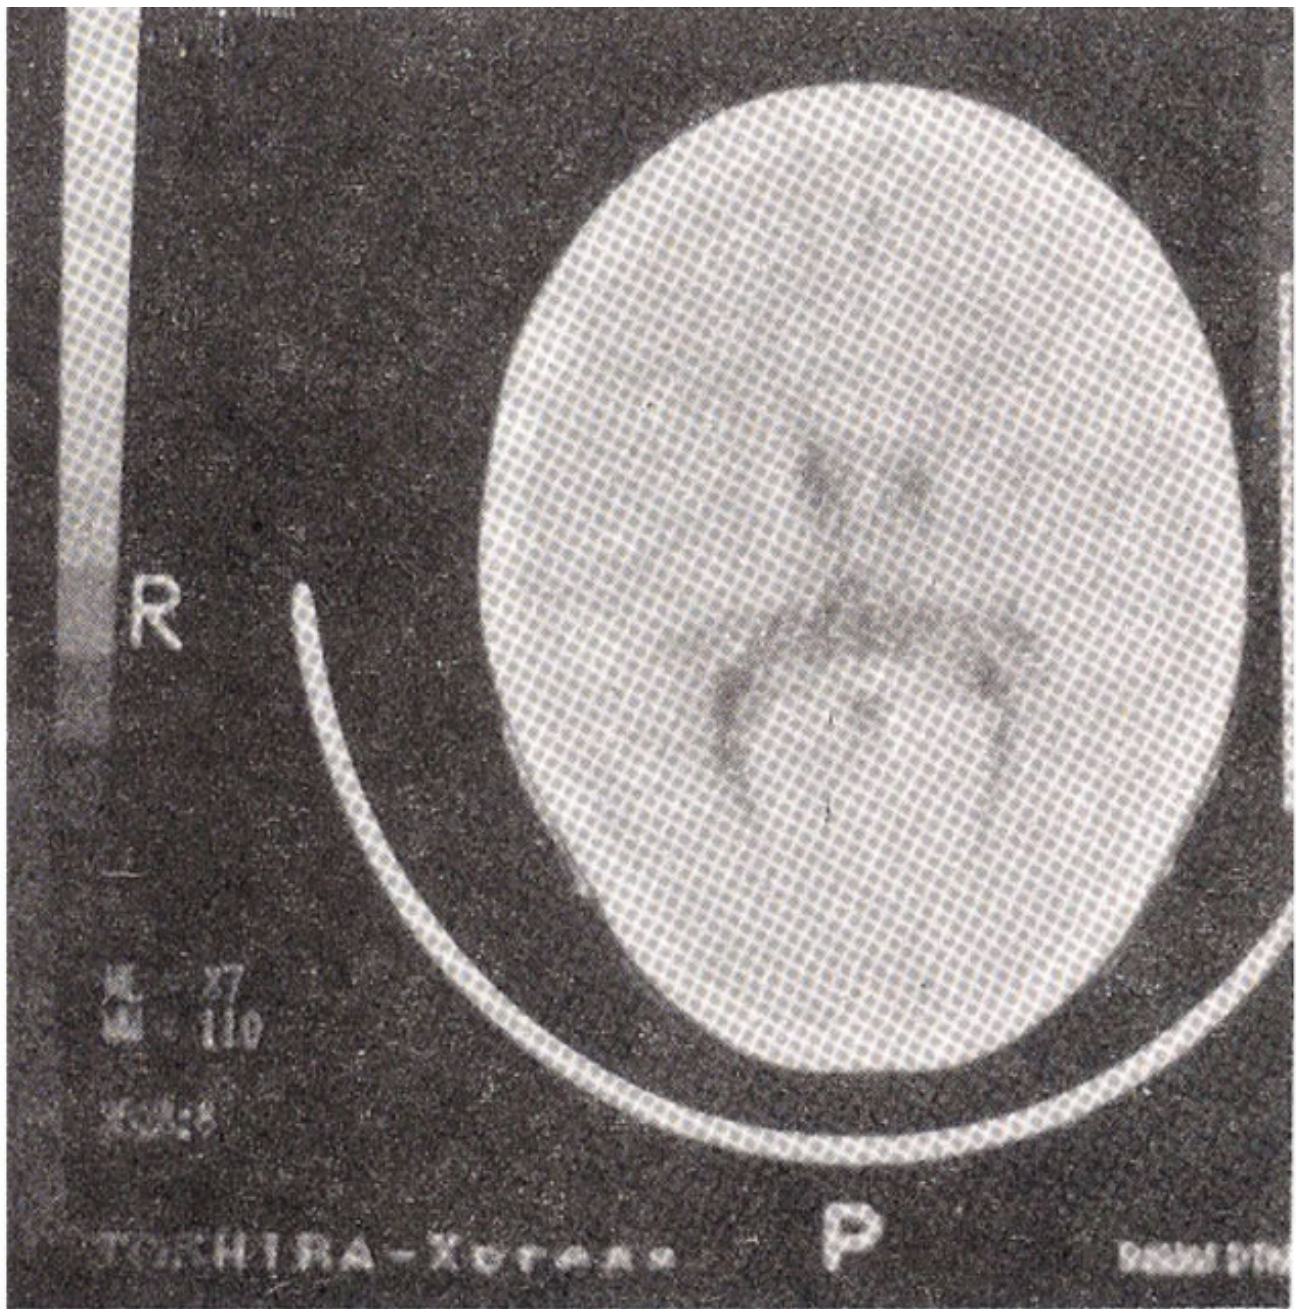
CT scan brain showing symmetrical hypodense lesions in the white matter around the posterior horns of lateral ventricles.
